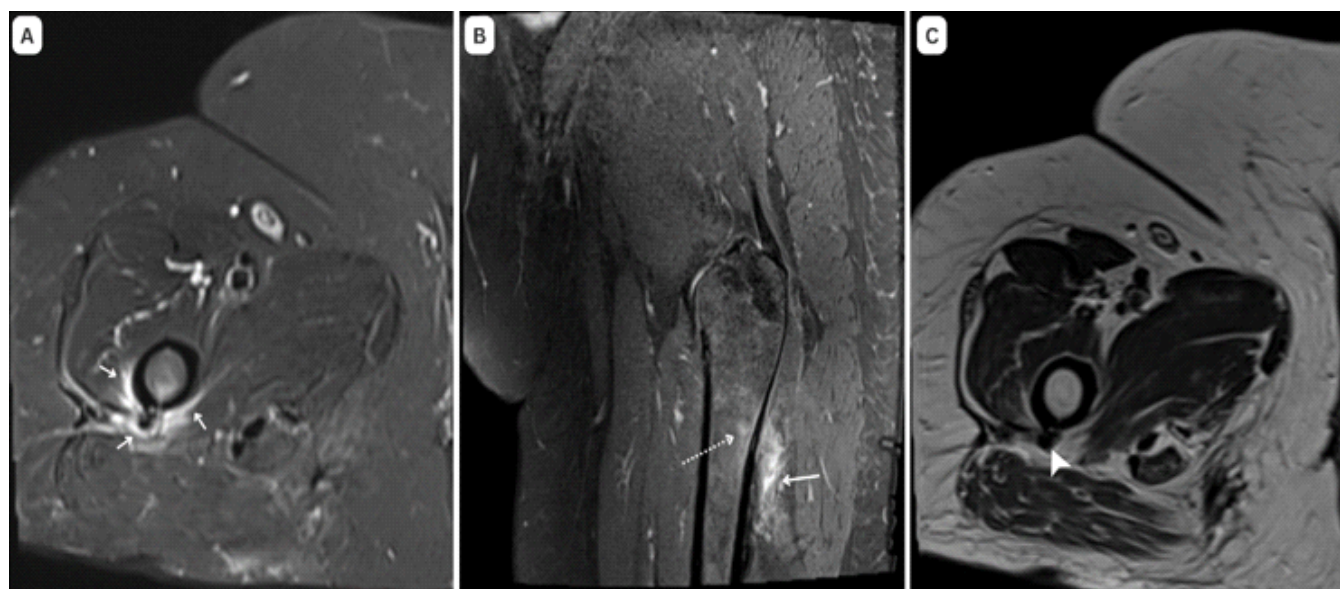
Magnetic resonance imaging axial T2-weighted fat-suppressed (a) and coronal T2-weighted fat-suppressed (b) images of the proximal right thigh demonstrate peri-osseous edema, subtle marrow edema (dotted arrow), and edema within the muscles attaching to the linea aspera (solid arrow) – gluteus maximus, adductors, and vastus lateralis. Axial T2-weighted image (c) reveals a corresponding hypointense focus (arrowhead), suggestive of calcification.
